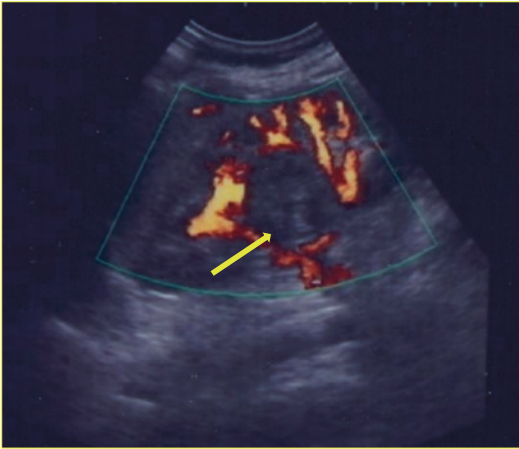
Acute hemorrhage after ultrasound-guided puncture of simple renal cysts (power Doppler)
